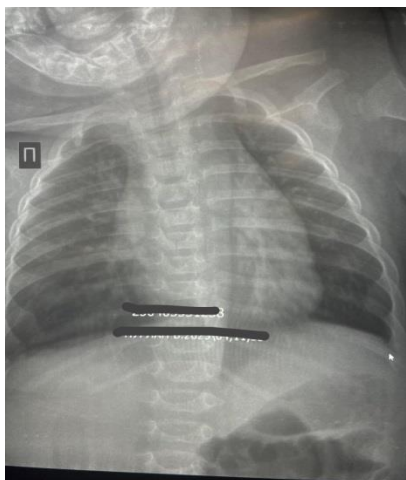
In Patient No. 4, no radiographic evidence of pneumonia was observed on the chest radiograph on day 1 of illness.
